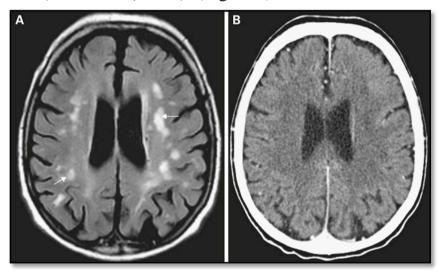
Leukoaraiosis on (flair) images and CT scan brain (Jean et al., 2011) (MRI, axial Flair-weighted images (A). Presence of multiple signal abnormalities in the deep white matter (white arrows) corresponding to leukoaraiosis. CT scan of the same patient (B): the lesions are much less well demonstrated).
